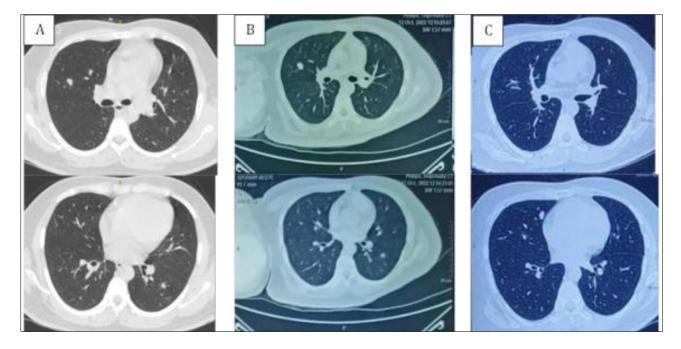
CT scan thorax (A) Pre-op, (B) Post Neoadjuvant chemotherapy, (C) Post-op
